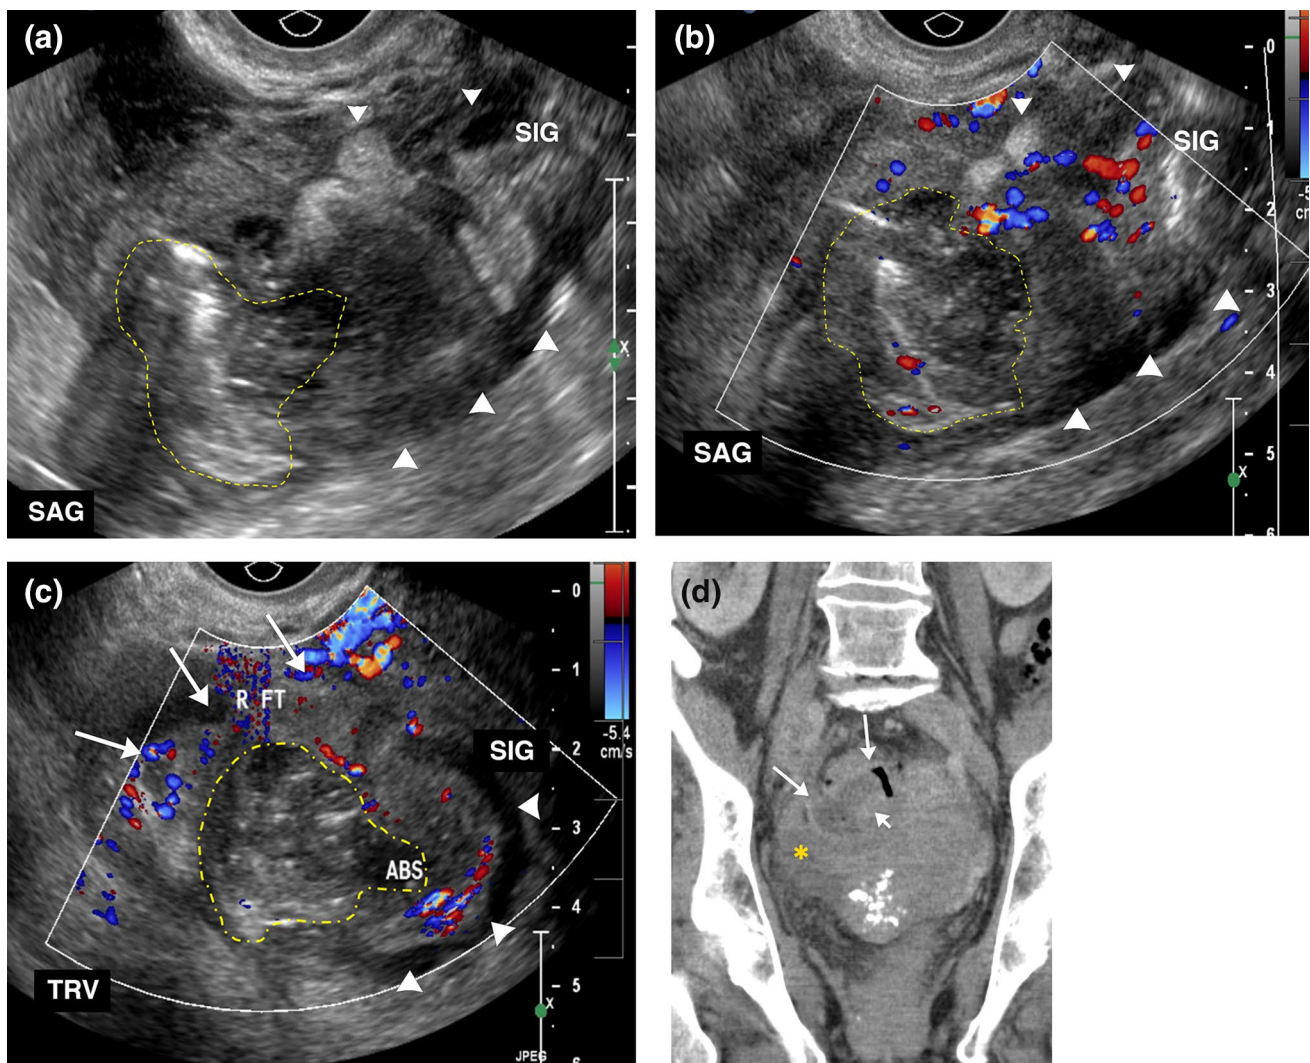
Acute diverticulitis with perforation and abscess formation in a 74-year-old female who presents to the emergency department with vague right pelvic pain. a Gray scale and b Color Doppler ultrasound images obtained in sagittal plane and c color Doppler ultrasound image in oblique/transverse plane through a transvaginal approach demonstrate a complex fluid collection (yellow dash lines in a–c) with echogenic foci within it representing gas. These findings are compatible with an abscess. Peripheral hyperemia is noted around
